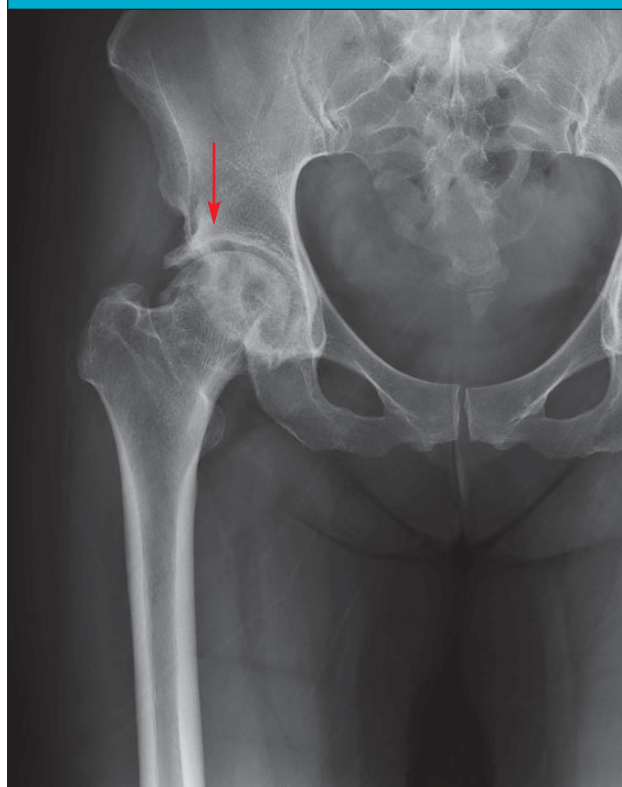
X-ray Image of Female Patient With Osteoarthritis of the Right Hip
